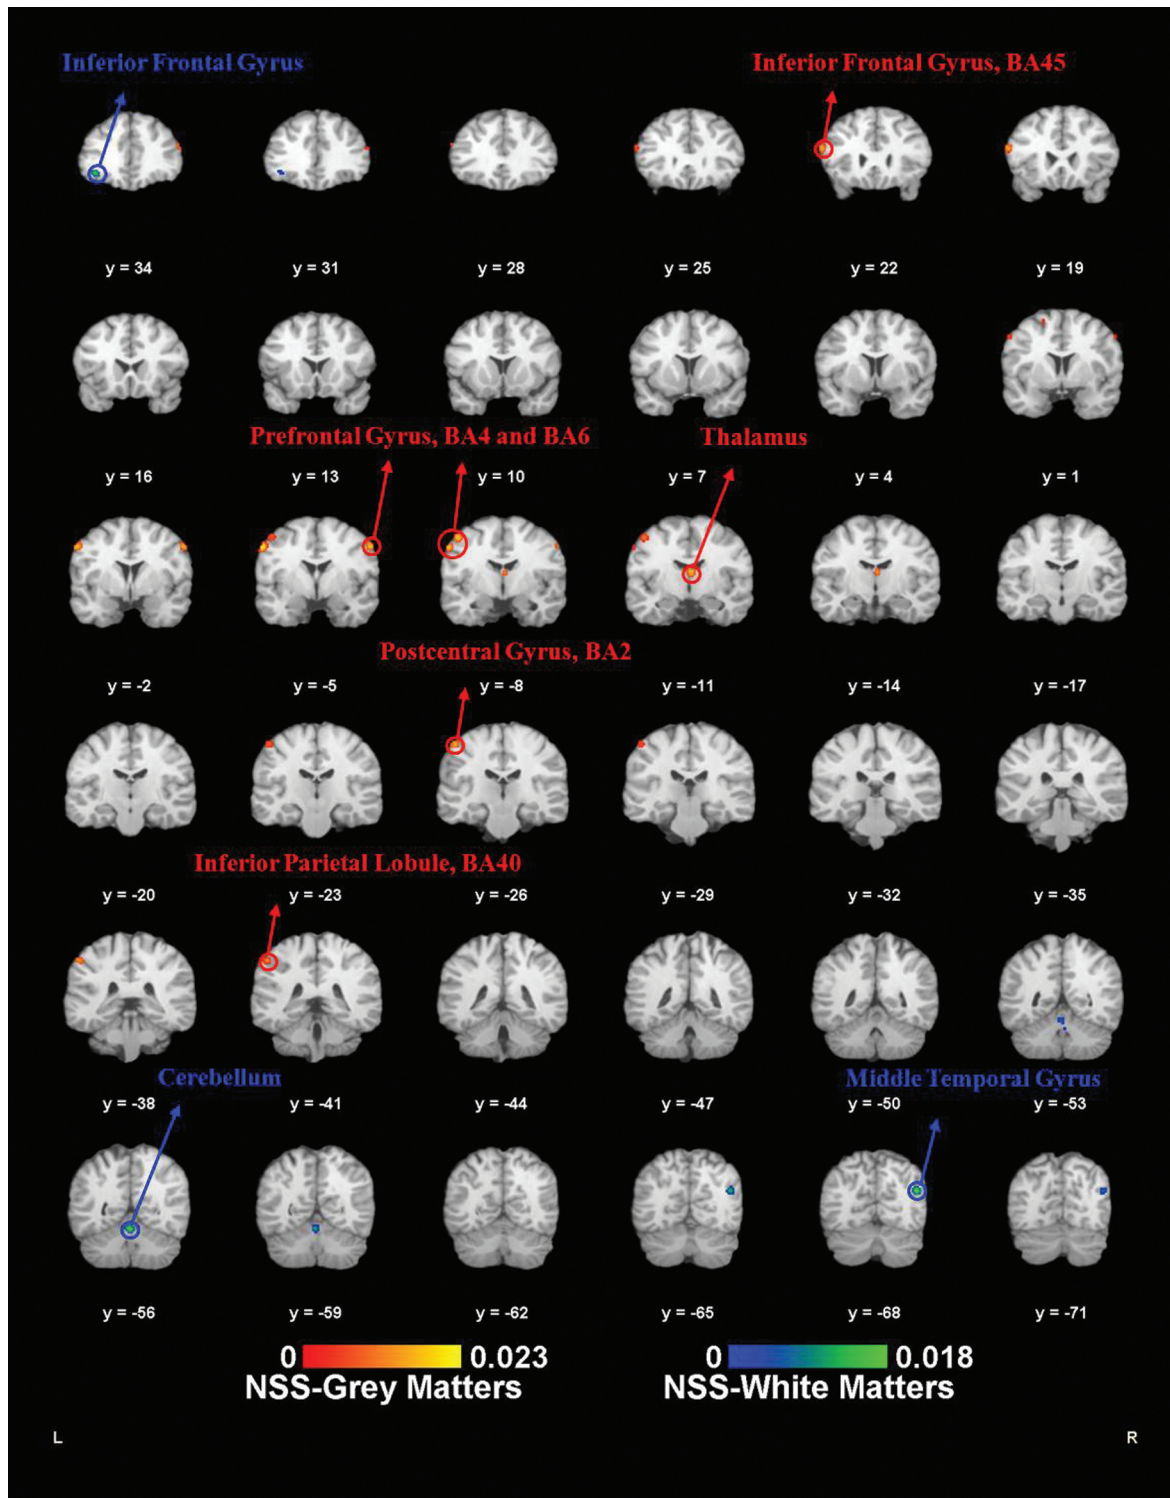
Activation likelihood estimation-structural magnetic resonance imaging (ALE-sMRI) results. ALE meta-analysis results of the sMRI. Red labels (neurological soft signs [NSS] gray matters) are the ALE meta-analysis results of the NSS scores negative correlated gray matter foci. Blue labels (NSS white matters) are the ALE meta-analysis results of the NSS scores negative correlated white matter foci ($P < .05$, false discovery rate [FDR] corrected).
